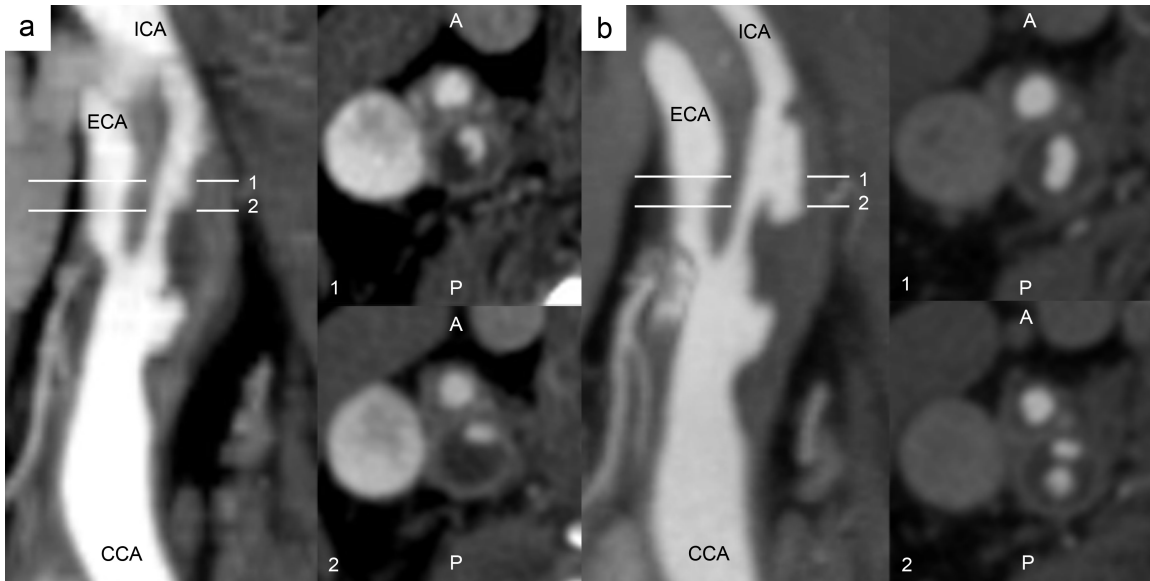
CTA studies at a) baseline and b) 8 months later. a) luminal geometry in the longitudinal plane (left) and transverse to the lumen for slices 1 and 2 (right). Note the irregular luminal geometry proximal to the bifurcation, suggesting existing ulceration of common carotid artery plaque. b) Slice 1 shows increased lumen area in the internal carotid artery consistent with plaque rupture, while slice 2 shows that a portion of the plaque core inferior to the rupture location has emptied after fibrous cap failure.
